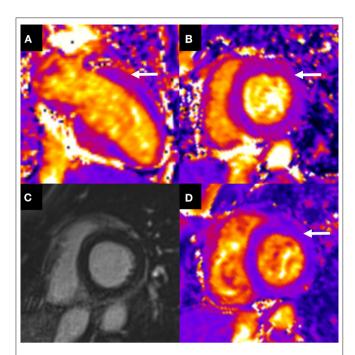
Initial cardiac MRI and follow-up. Cardiac MRI at day 3 after transfer to the nephrology intensive care unit, showed (A,B) an elevation of basal T2 mapping value $(60 \pm 5 \text{ ms})$ related to myocardial edema (arrows) not involving the mid and apical left ventricle without late gadolinium enhancement (C). (D) One month later, short axis T2 mapping showed regression of the myocardial edema with a normal T2 mapping value $(49 \pm 1 \text{ ms})$ (arrow).
